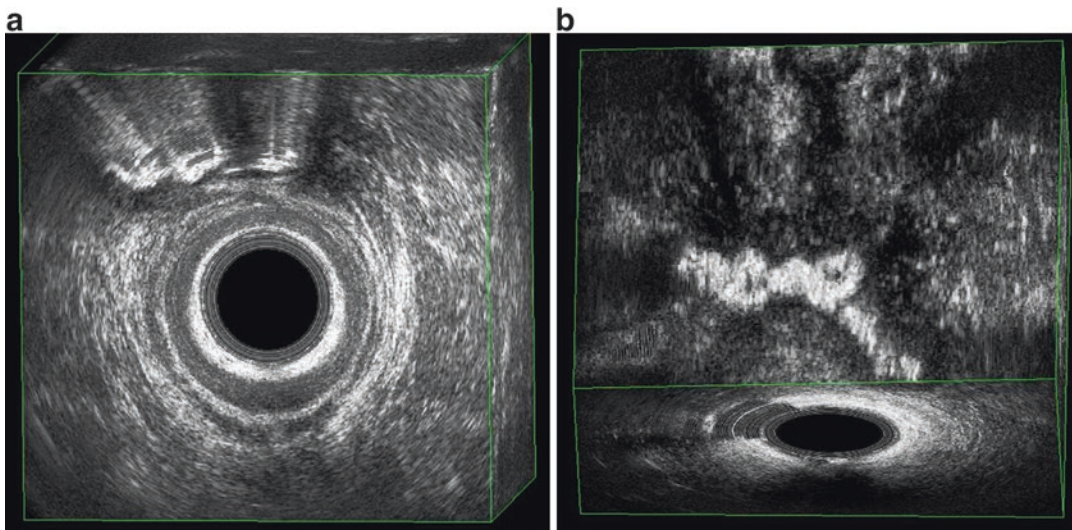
3D endoanal ultrasound with BK 2052 probe. (a) After injection of hydrogen peroxide, the fistulous tract appears hyperechoic. (b) Reconstruction in the coronal plane
